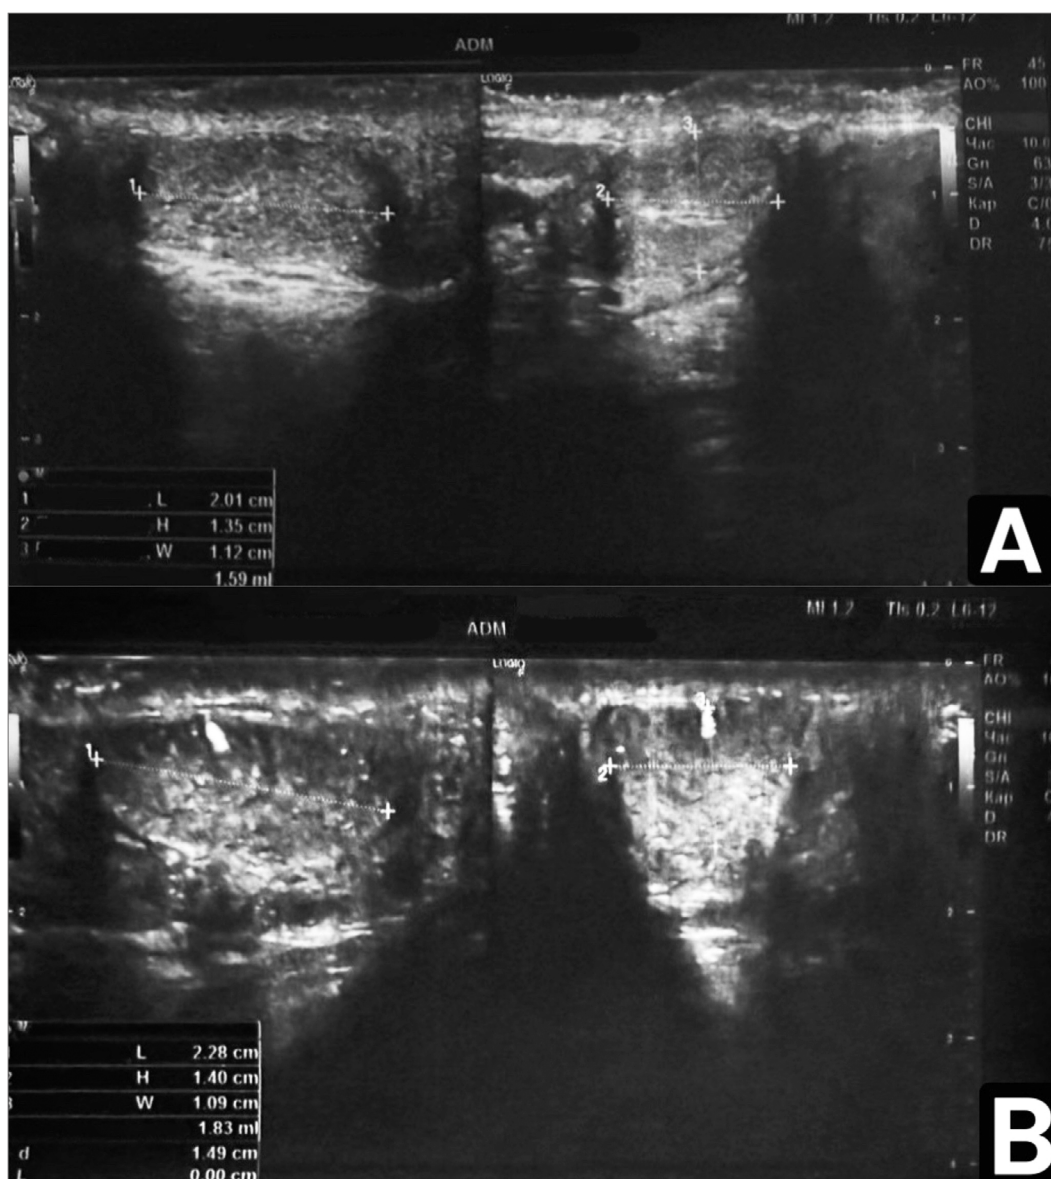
Scrotal ultrasound demonstrating bilateral testicular hypoplasia and testicular microlithiasis.
